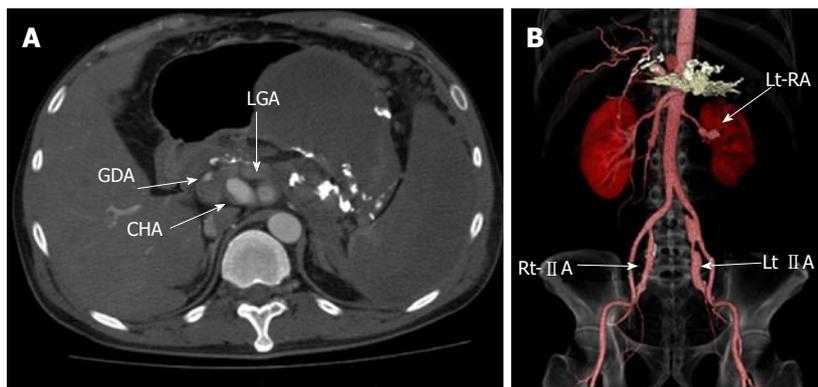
Enhanced computed tomography demonstrated six splanchnic artery aneurysms. GDA: Gastric duodenal artery; LGA: Left gastric artery; CHA: Common hepatic artery; Lt-RA: Left renal artery; Rt-IIA: Right internal iliac artery; Lt-IIA: Left internal iliac artery.
